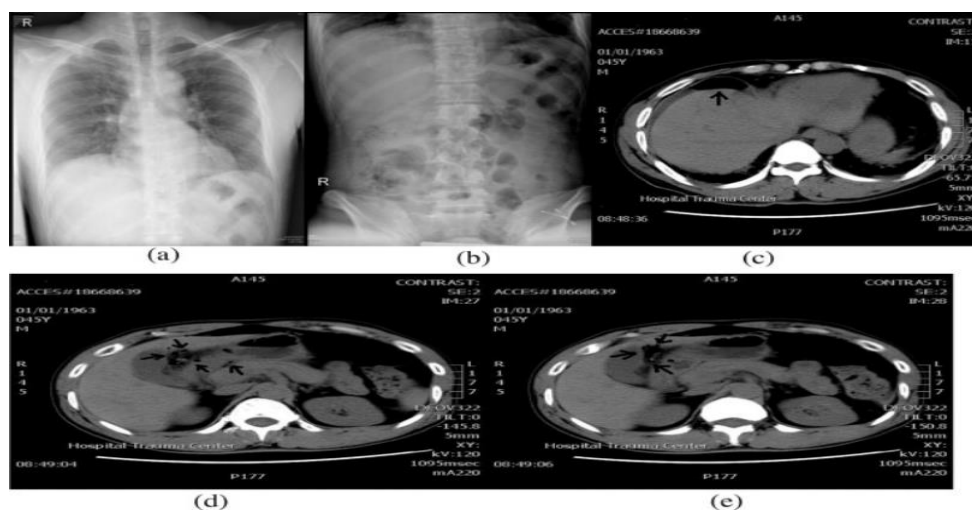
Perforated duodenal ulcer. Chest (a) and abdomen (b) AP sitting X-ray shows no obvious free air under the diaphragm. Axial (c–e) images show free intraperitoneal air and collection in the anterior peritoneal surface of the liver, and around the du.
